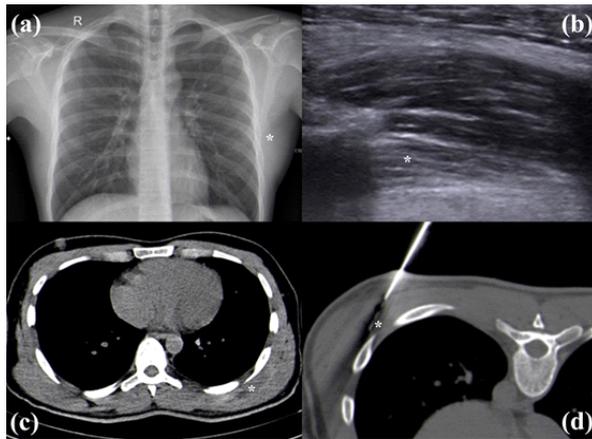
Elastofibroma Dorsi (asterix) of left infrascapular region seen on different imaging modalities: (a) Chest radiograph of the patient shows soft tissue prominence. (b) High resolution ultrasound shows alternating hypoechoic fat tissue and echogenic fibroelastic tissue. (c) Non contrast CT scan of the patient reveals a sheet of soft tissue thickening deep to the serratus anterior and latissimus dorsi muscles, along with thickening of the fascia overlying the serratus anterior muscle fibers. (d) CT guided biopsy of the lesion.
